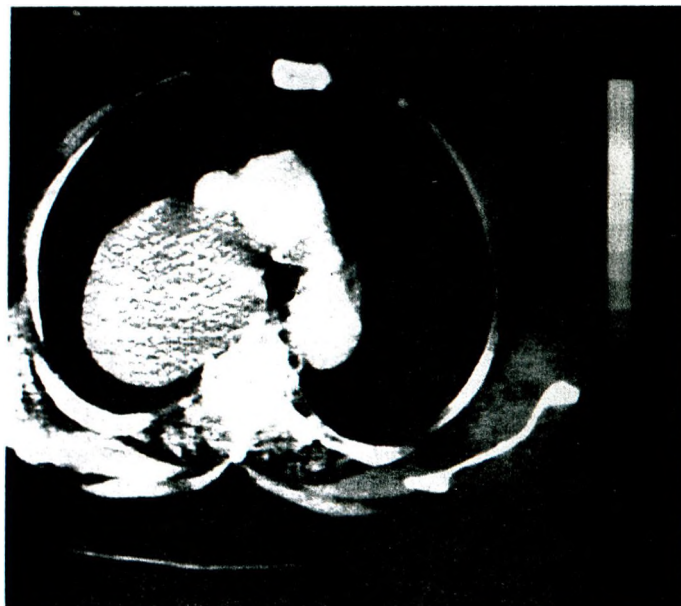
CT Scan of thorax showing a cystic mass in the right paratracheal area.
